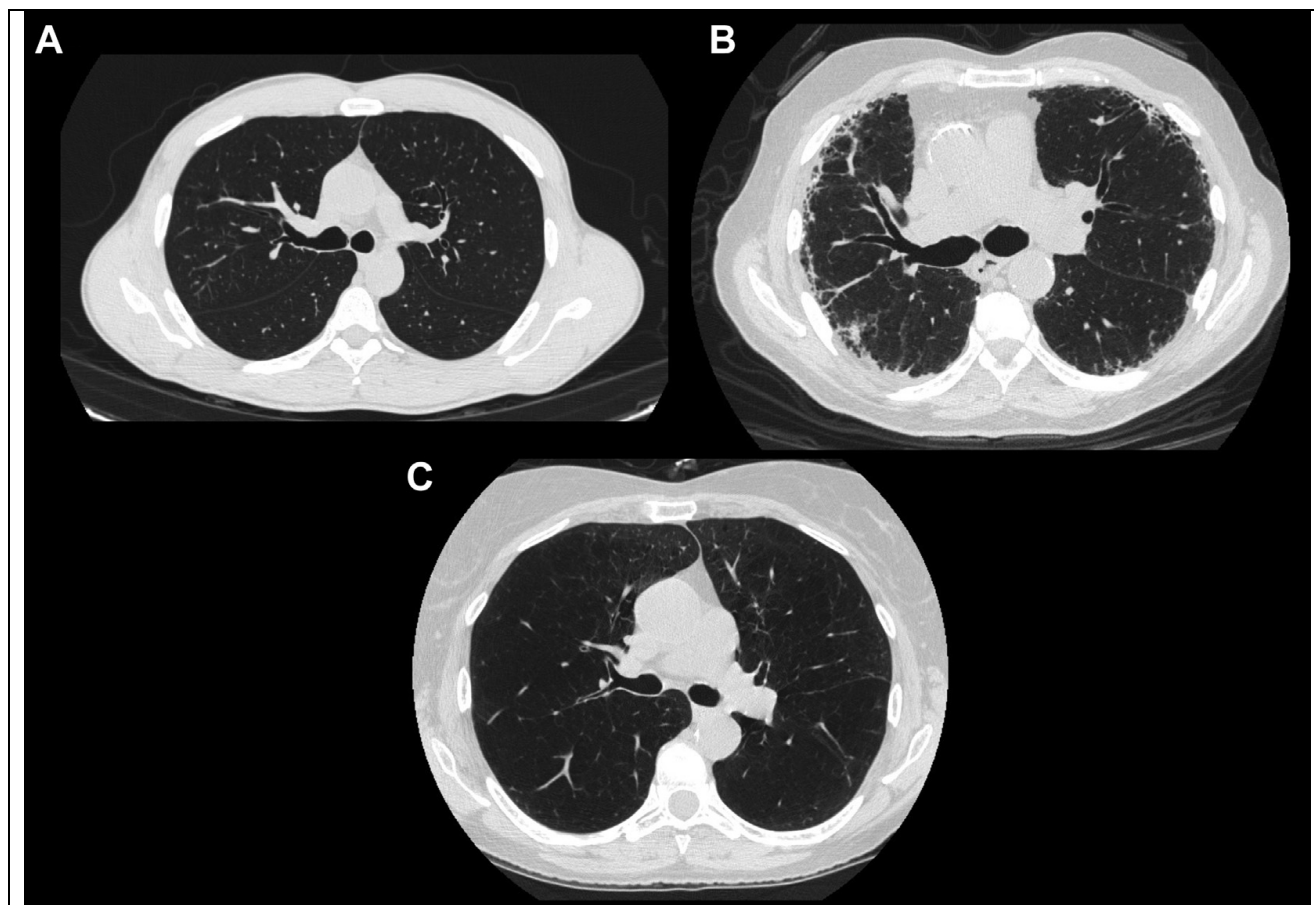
Representative CT images from the preserved parenchyma (A), interstitial predominant (B), and emphysema predominant (C). Taken from Billatos et al Chest 2021.
